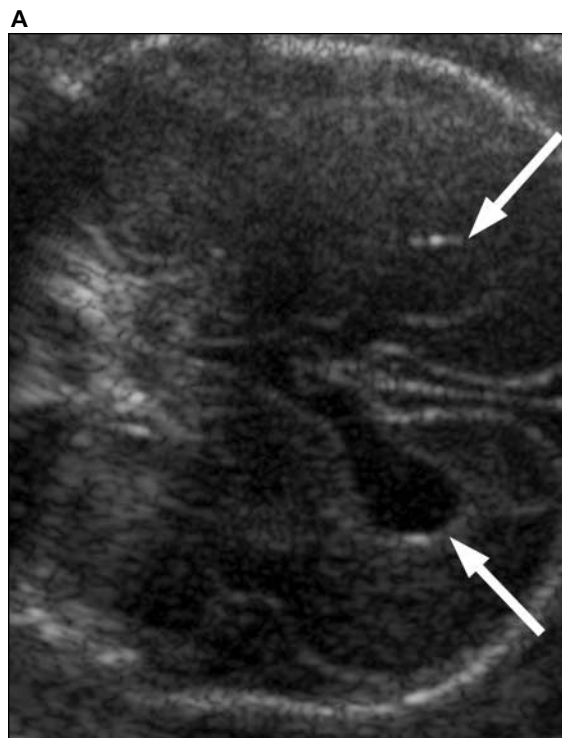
Images from a fetus at 23 gestational weeks with callosal hypogenesis (case 5). A, Oblique coronal sonogram showing a high-riding posterior third ventricle (arrow). B, Sagittal sonogram showing an intact anterior corpus callosum (arrow) with no posterior callosum identified, consistent with callosal hypogenesis. C, Hypogenesis of corpus callosum confirmed on sagittal SSFSE T2-weighted image (arrow). D, Axial SSFSE T2-weighted image showing additional MR findings of shallow sylvian fissures for gestational age (arrows) and poor distinction of parenchymal layers.
